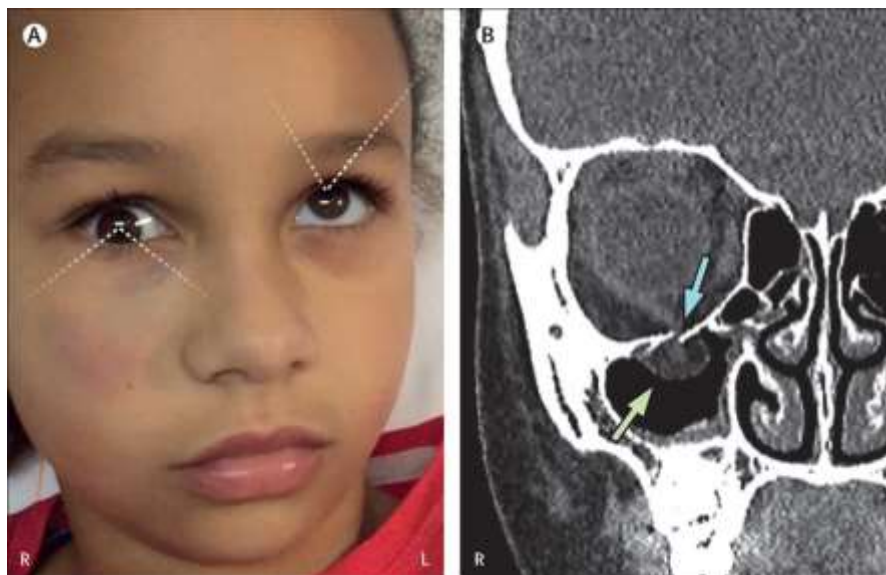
Haematoma around the right zygoma and an inability of the right eye to elevate; the white lines show the line of sight of each (A). A CT scan shows the orbital floor fracture (blue arrow) with herniation (green arrow) of the inferior rectus muscle and orbital soft tissue surrounding the muscle (B) (Kemps and Frank, 2020).
